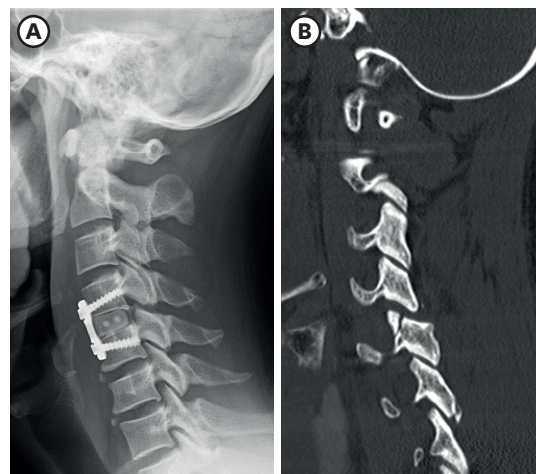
Post-op imaging. Post-op cervical lateral X-ray (A) and sagittal CT images (B) showed that vertebral bodies are in good alignment and the fracture fragment is in place.
